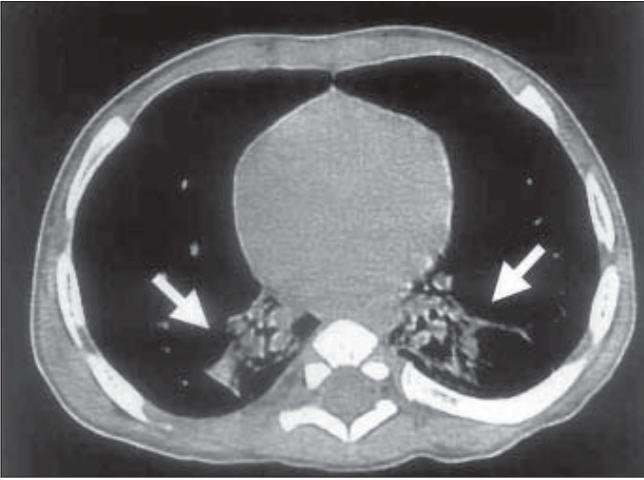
CT scan thorax showing emphysematous right middle and lingula with collapsed lower lobes
